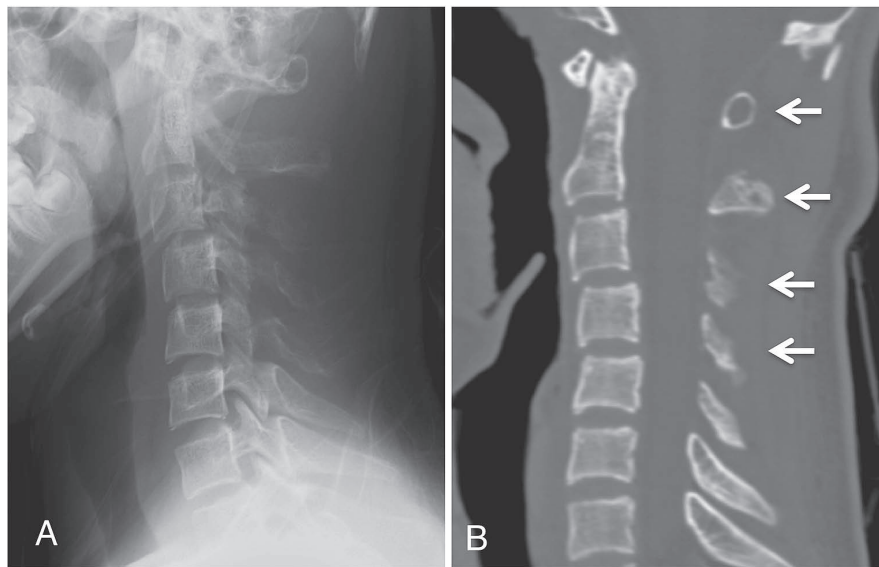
Plain radiograph and computed tomography (CT) of the cervical spine on admission. Osteolytic changes were observed in the vertebral bodies, laminae, and spinous processes from C1 to C5. The cortical bone was thinned and small radiolucent foci were observed in the spinal bone (arrows) (A: plain lateral radiograph; B: sagittal reconstructed CT).
